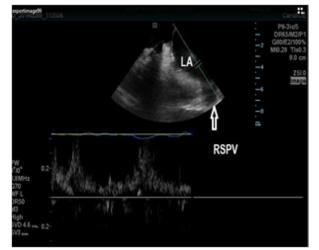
Intracardiac echocardiography with the echo probe inserted in the middle of the right atrium. Pulsed Doppler flow at the level of right superior pulmonary vein.
